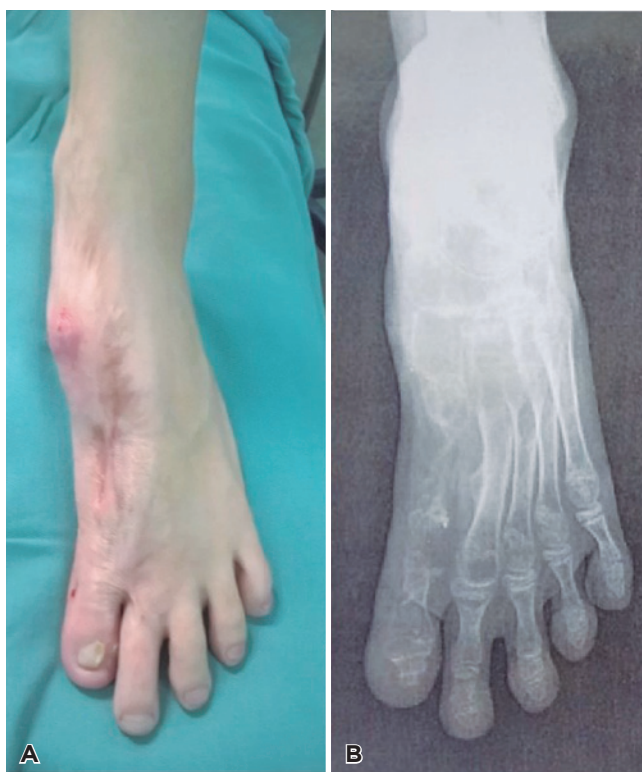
A) Postoperative appearance and radiography. B) After external fixator removal.
